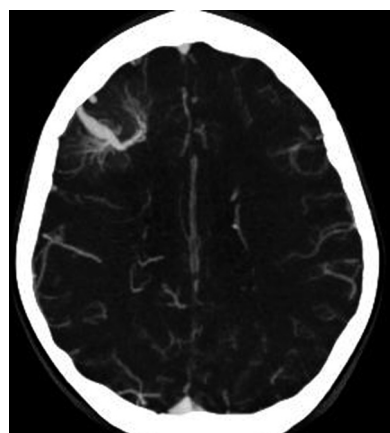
Computed tomography angiography: typical developmental venous anomaly in the right frontal lobe.
